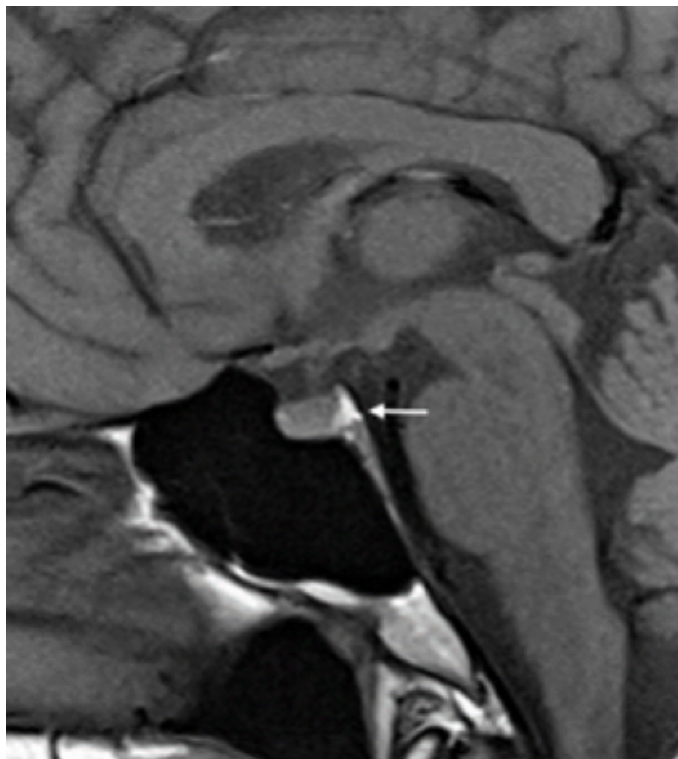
Magnetic resonance imaging (MRI) of the pituitary gland. The above image is a non-contrast T1 MRI image of a normal pituitary gland. The white arrow points towards the ‘bright spot’ seen in the posterior pituitary. This finding is a result of phospholipid-rich granules that store arginine vasopressin (AVP) and oxytocin. Image courtesy: NIDDK, NIH.
